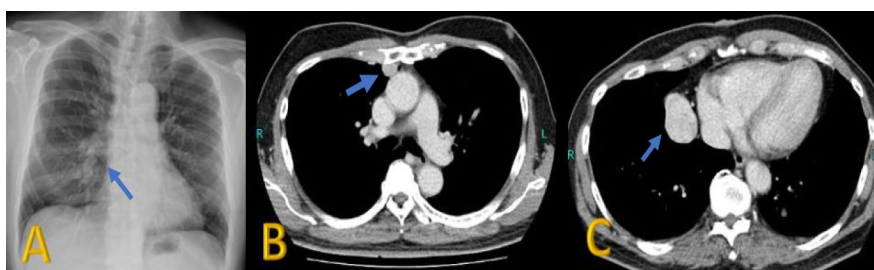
(A): chest x ray showing lesions in the right lung and chest CT scan showing a substernal tumor in (B) and a pulmonary tumor in the right lung (C) (arrows).
